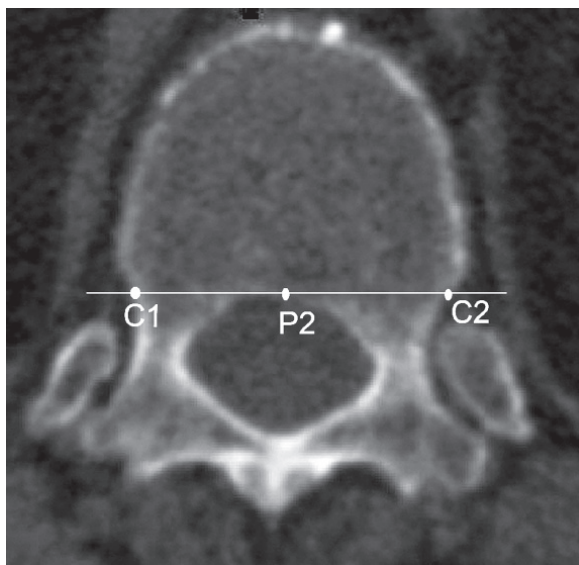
The transverse dimension (TD) at T11 and T12 (transverse CT): "P2" is the posterior margin of the vertebral body; "C1C2" is TD at T11 and T12.
